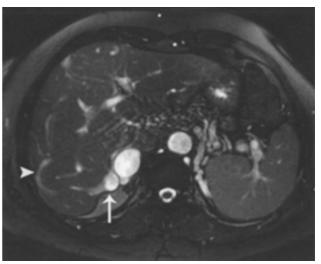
Axial balanced turbo field echo magnetic resonance image showing the inferior accessory hepatic vein (arrow). Arrowhead indicates an intrahepatic venous collateral directed towards the inferior accessory hepatic vein. At this level, multiple collaterals at the splenic hilum are also observed
